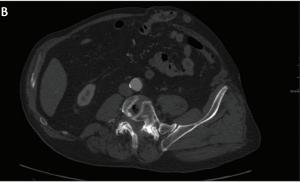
Sagittal CT showing abnormal aneurysm neck morphology in detail. At the level of the renal arteries, the aorta measured 26 mm, narrowed to 24 mm, and then flared out to 26 mm (A). Axial CT image of the distal aorta showing the narrowest point measuring 16 mm (B).
